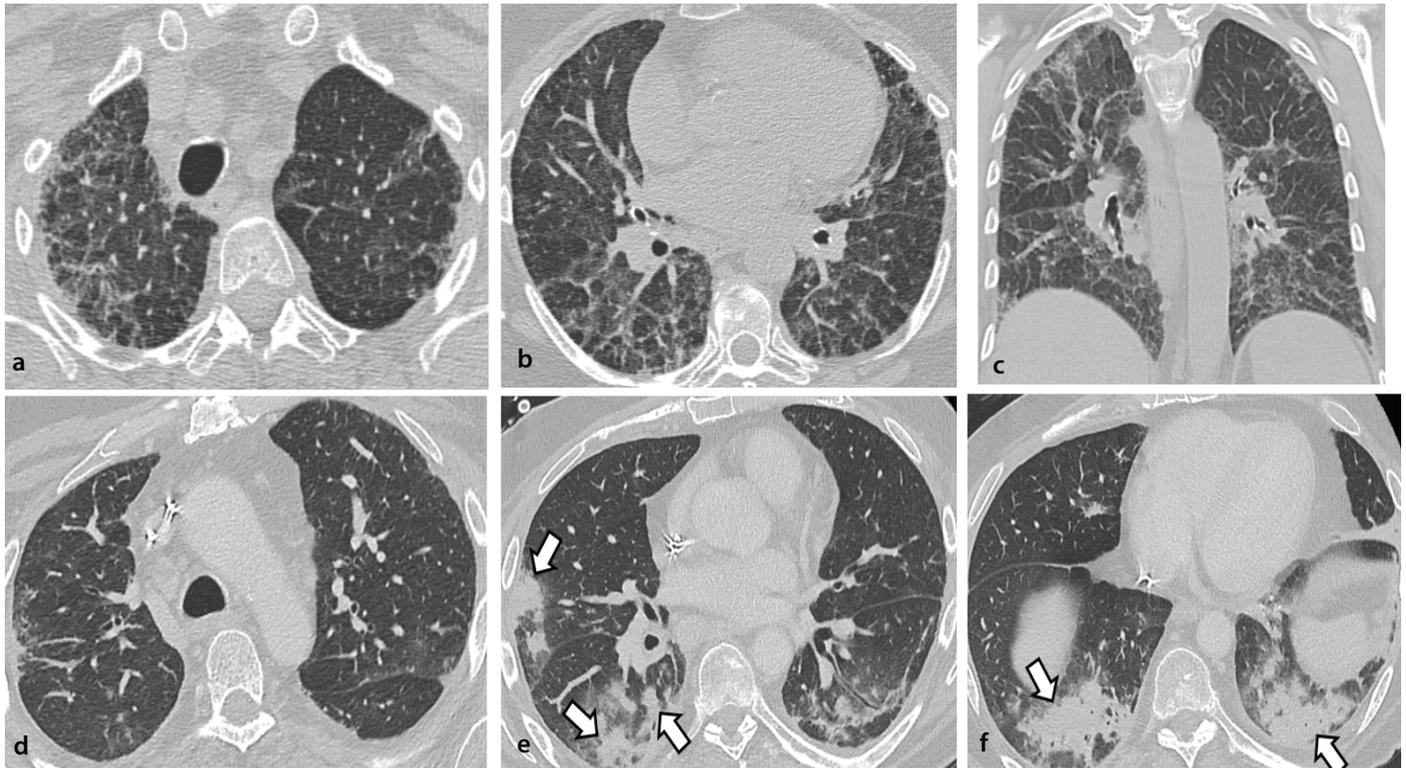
Eosinophilic pneumonia patterns on chest computed tomography (CT). Axial (a, b) and coronal (c) CT images demonstrate chronic eosinophilic pneumonia, characterized by peripheral, upper-lobe–predominant ground-glass opacities (GGOs), architectural distortion, and reticulations in a patient with a subacute-to-chronic clinical course. Axial CT images (d–f) demonstrate acute eosinophilic pneumonia with bilateral patchy consolidations (arrows) and ground-glass opacities in the setting of acute respiratory symptoms.
